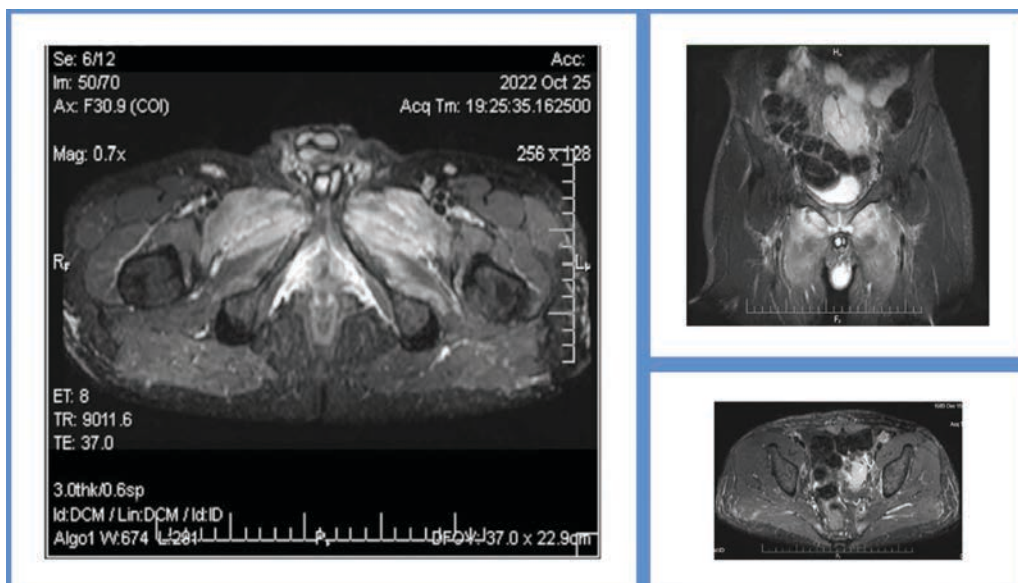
Follow-up MRI maintaining muscular and bony oedema and lesser quantity of fluid
